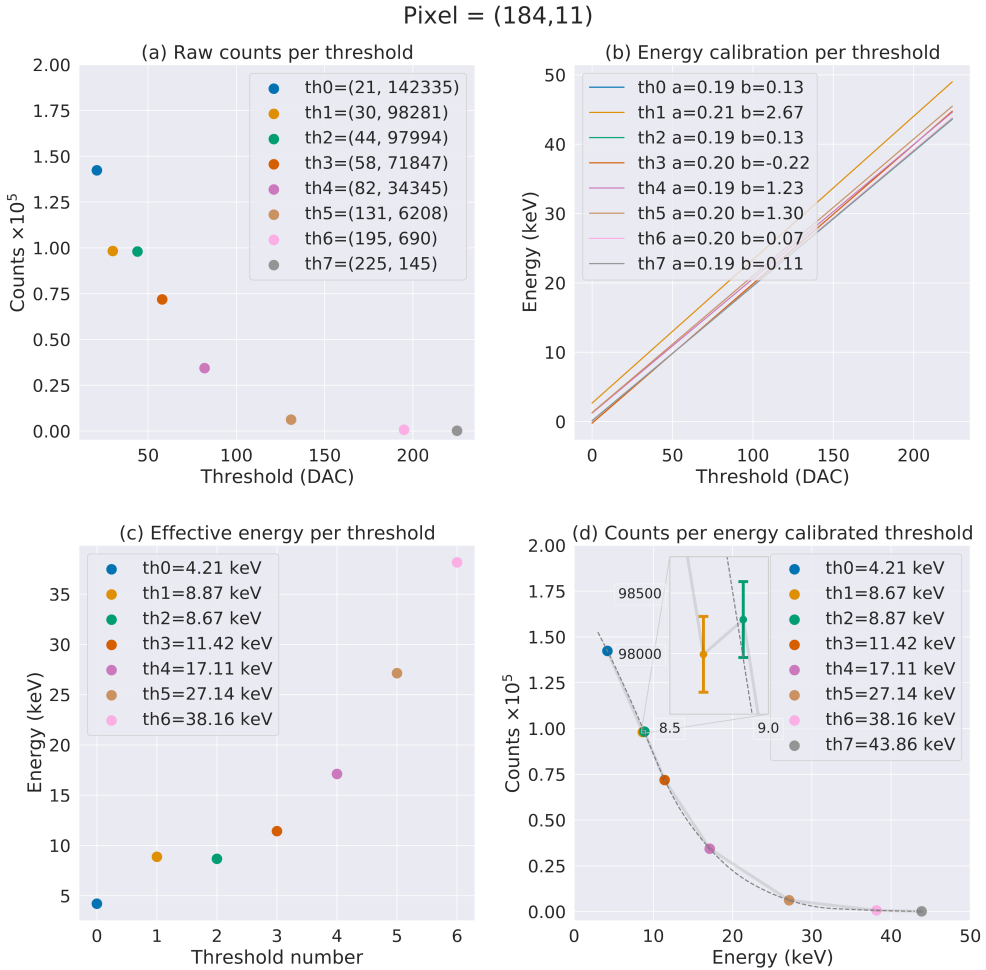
An overview plot of the energy calibration per pixel process. This used all eight thresholds and an arbitrary pixel was chosen with coordinates of $x = 184$ and $y = 11$. A Si based detector was used in SPM with a peak x-ray tube voltage of 50 kVp. The thresholds were set from 21 to 225 DAC units as seen in (a). The energy calibrations per threshold are in (b). This leads to the effective energy per threshold for this pixel in (c). Finally, the counts per energy calibrated threshold are shown in (d), the uncertainties plotted are the photon counting errors, \sqrt{N} .
